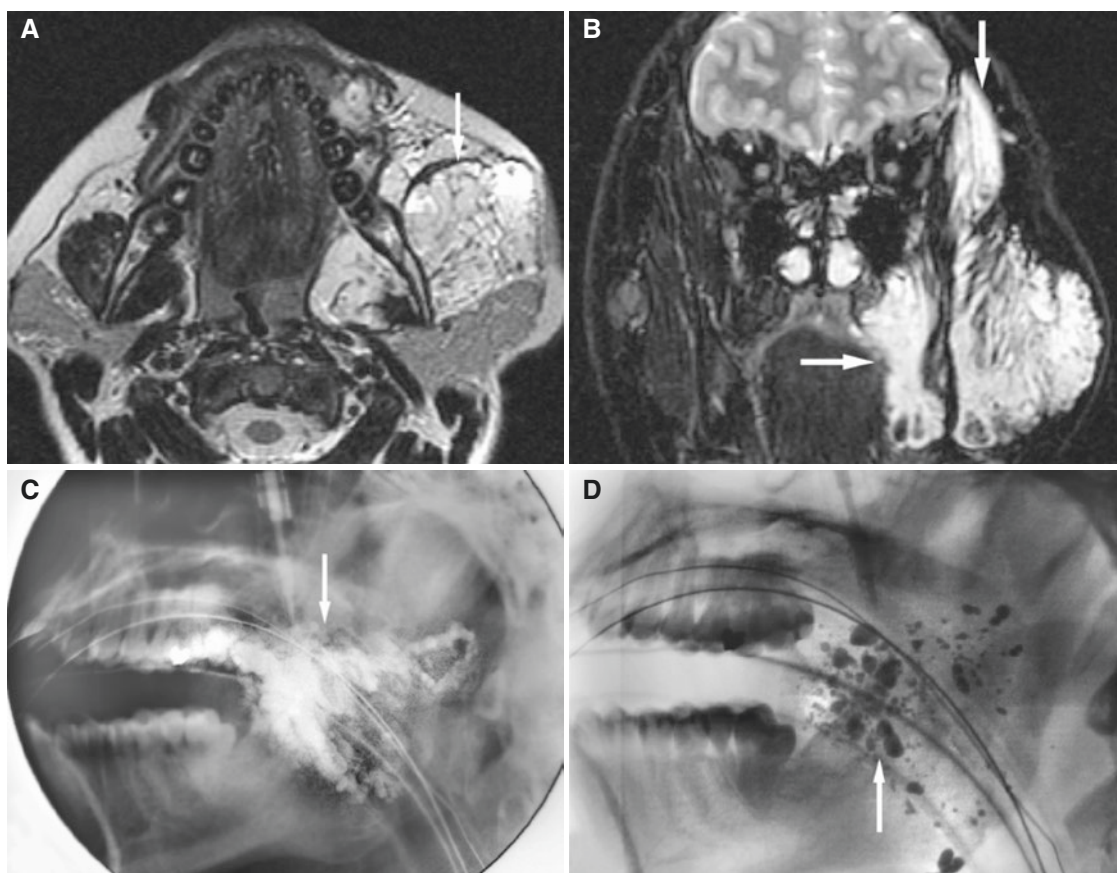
Facial hemangioma embolization. (A) Axial T1-weighted fat-suppressed post-Gd MRI shows hemangioma located in the left masticator space (*arrow*). (B) Coronal T2-weighted fat-suppressed MRI shows large mass of infiltrating nature (*arrows*). (C) Lateral view (fluoroscopy) shows percutaneous injection of hemangioma (*arrow*)
